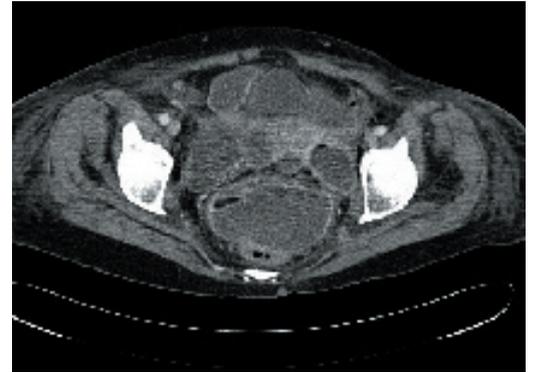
CT Scan showing response to CT guided aspiration.
